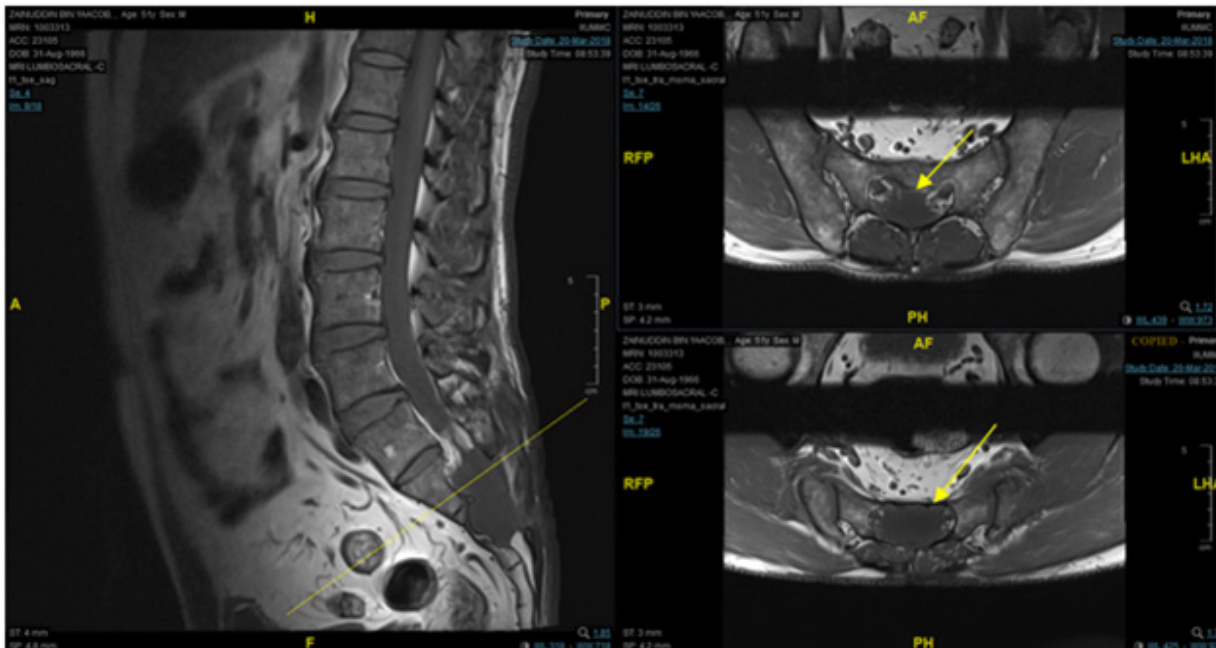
T1-weighted lumbosacral MRI images. Sagittal (a), axial (b, c) views show the well-defined cystic structure (yellow arrow) at the S1 vertebra (b) and the S2 vertebra (c). Preoperative magnetic images demonstrating a hypointense lesion in T1-weighted MRI.
